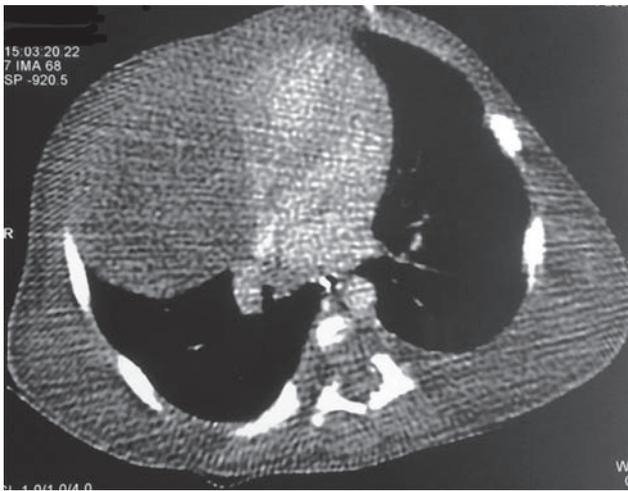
Chest CT shows an anterior mediastinal mass extending into right hemithorax.
